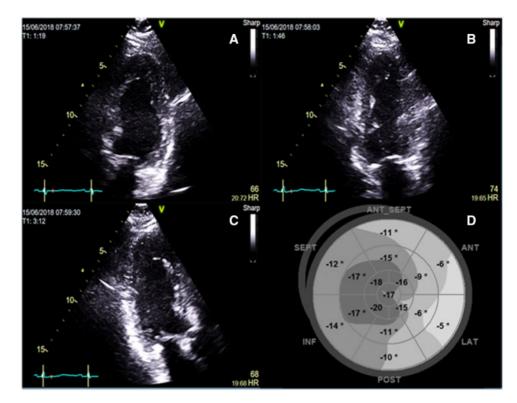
Typical echocardiogram assessment during HD. (A) Apical four-chamber view, (B) apical two-chamber view, (C) apical three-chamber view. Images A and B were used to calculate LV stroke volume, cardiac output, ejection fraction and end-diastolic and -systolic volumes with the Simpson's biplane method. Images A–C were used for GLS and RWMA assessment, and subsequently, a bullseye plot was produced (D). Dark grey indicates higher longitudinal strain with light grey and white indicating progressively lower longitudinal strain (hypokinesia). A score of 0 (white) indicates myocardial segment akinesia.
